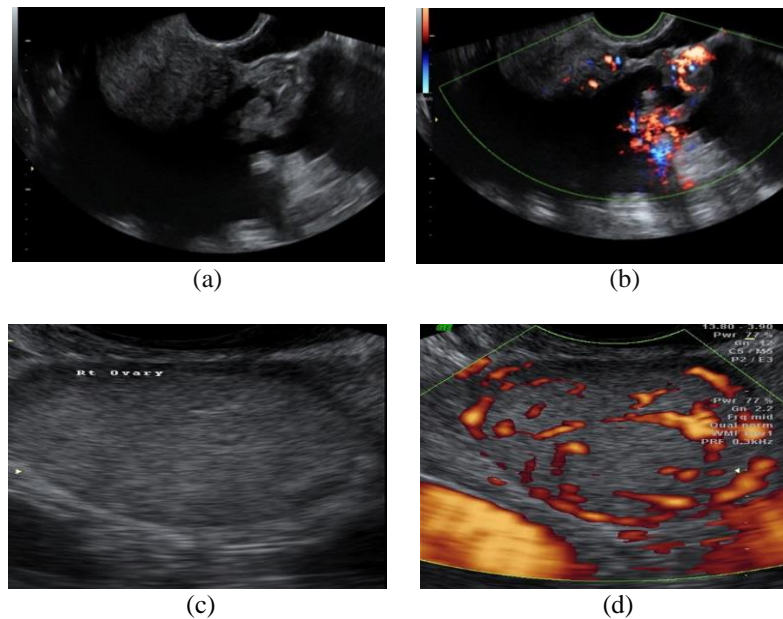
10: Examples of 2D US images of colour Doppler (a) US image of ovarian tumours (b) Colour Doppler US image of ovarian tumour (c) US image of ovarian tumours (d) Colour Doppler US image of ovarian tumour
